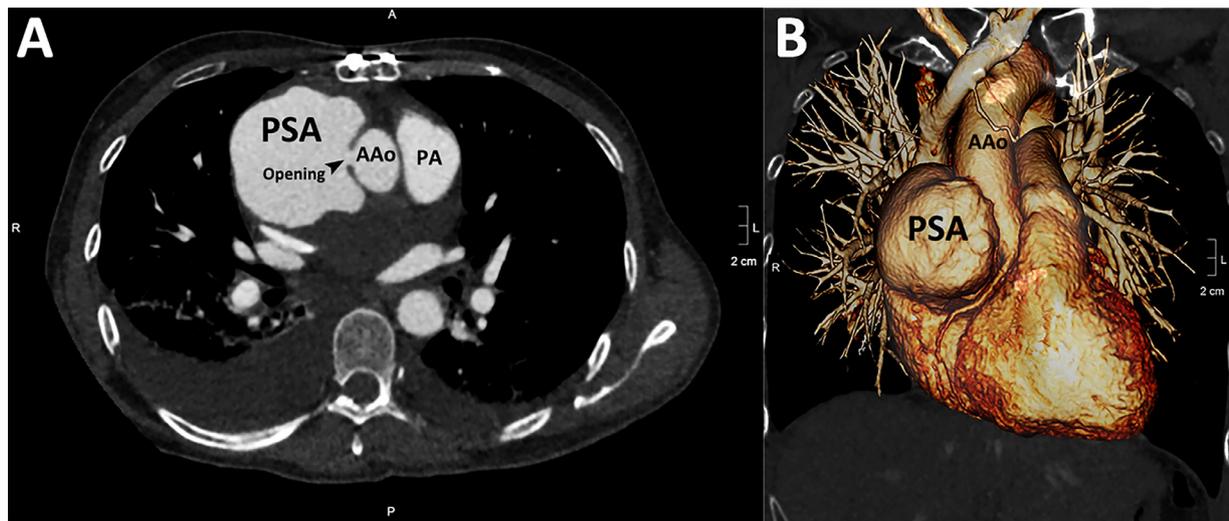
(A) Computed tomographic angiography and (B) three-dimensional reconstruction revealed an ascending aortic pseudoaneurysm (7.6 cm × 6.4 cm) with bilateral pleural effusion. AAo, ascending aorta; PA, pulmonary artery; PSA, pseudoaneurysm.
